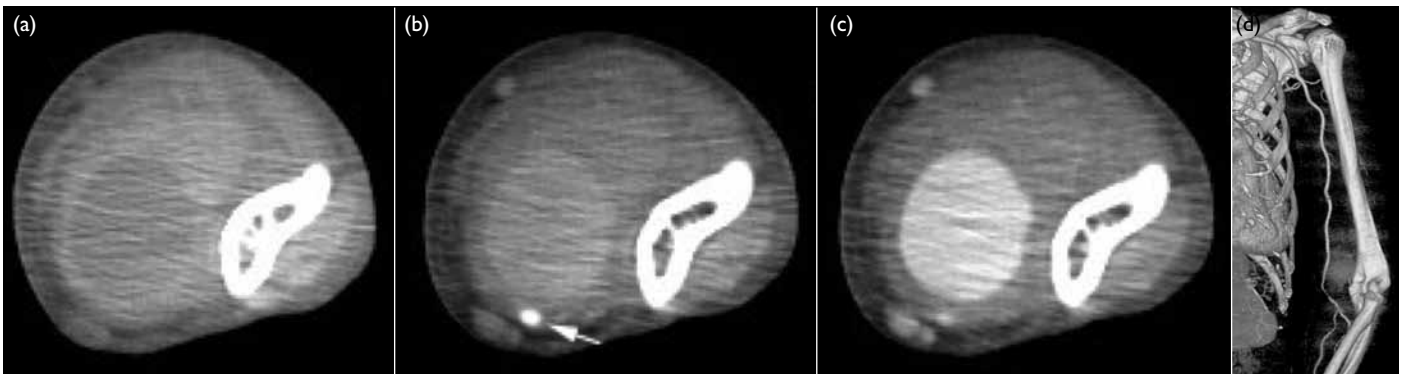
An 80-year-old man (patient No. 2) after removal of a left brachial arterial line. Ultrasound (not shown) showed a vascular lesion near the left distal humerus, but its relationship with the brachial artery was not well-demonstrated
